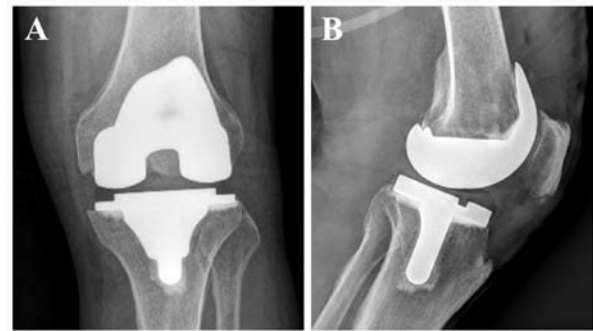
(A) Anteroposterior view and (B) lateral view of the X-ray after the total knee arthroplasty.
